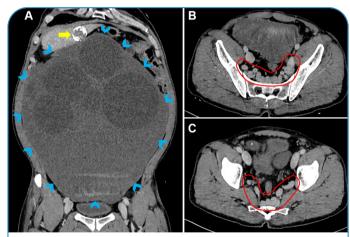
Coronal abdominal computed tomography (CT) scan (A) reveals a giant peritoneal hydatid cyst (arrowheads) and a calcified hepatic cyst (yellow arrow). Axial pelvic CT scans (B and C) reveal multiple dilated and tortuous pelvic venous structures (circle) in the presacral area.
